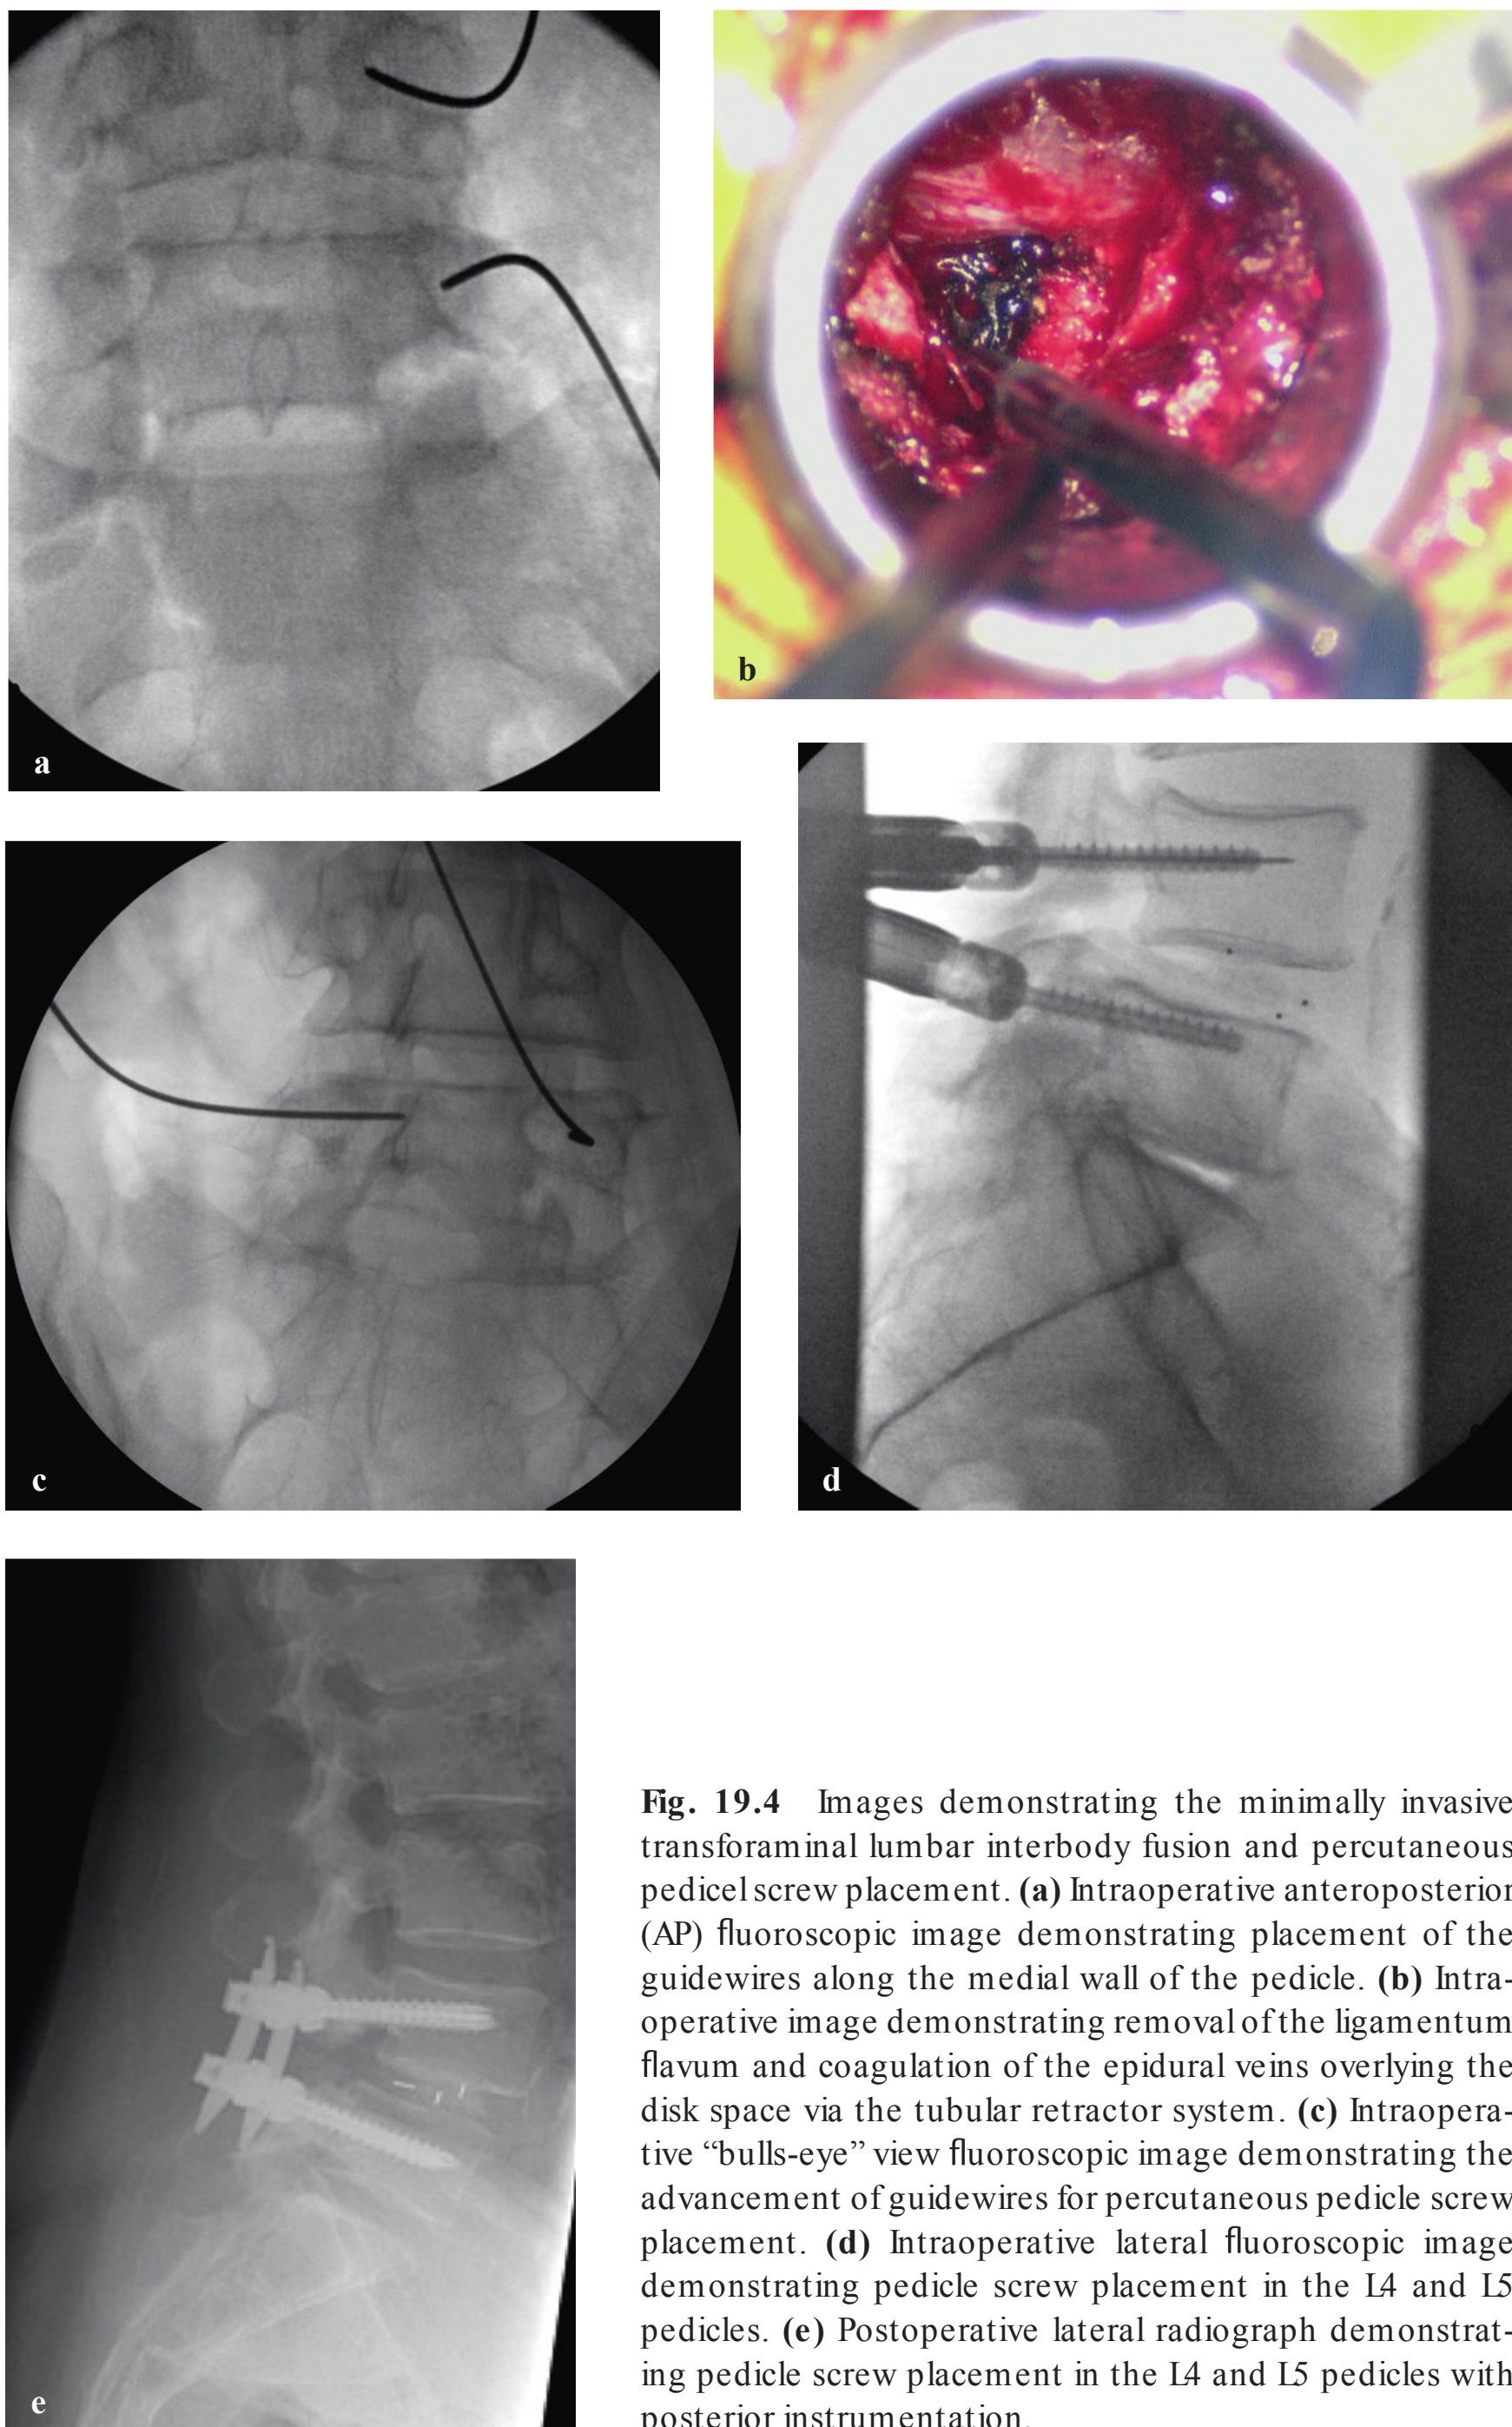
Images demonstrating the minimally invasive transforaminal lumbar interbody fusion and percutaneous pedicle screw placement. (a) Intraoperative anteroposterior (AP) fluoroscopic image demonstrating placement of the guidewires along the medial wall of the pedicle. (b) Intraoperative image demonstrating removal of the ligamentum flavum and coagulation of the epidural veins overlying the disk space via the tubular retractor system. (c) Intraoperative “bulls-eye” view fluoroscopic image demonstrating the advancement of guidewires for percutaneous pedicle screw placement. (d) Intraoperative lateral fluoroscopic image demonstrating pedicle screw placement in the L4 and L5 pedicles. (e) Postoperative lateral radiograph demonstrating pedicle screw placement in the L4 and L5 pedicles with posterior instrumentation.
